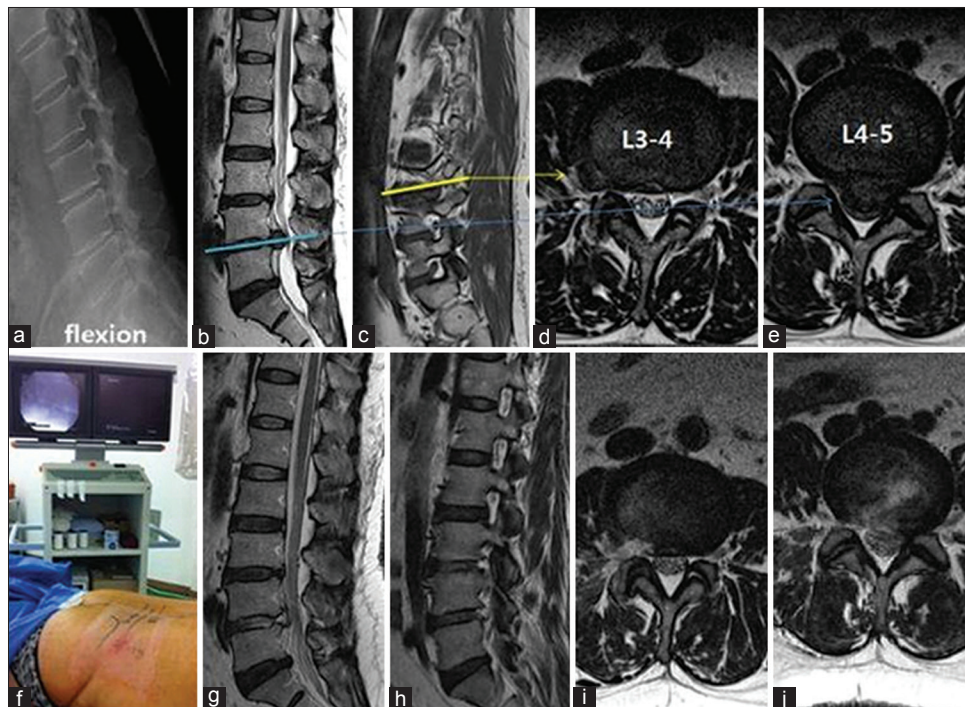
Preoperative magnetic resonance images (MRI) show left far lateral type L3-L4 disc herniation and high canal compromised type of L4-L5 lumbar disc herniation (a-e). Simultaneous endoscopically 2 adjacent level discectomy was performed by one portal skin incision (f). Postoperative MRI show herniated disc materials removed successfully in L3-L4 and L4-L5 (g-j)
